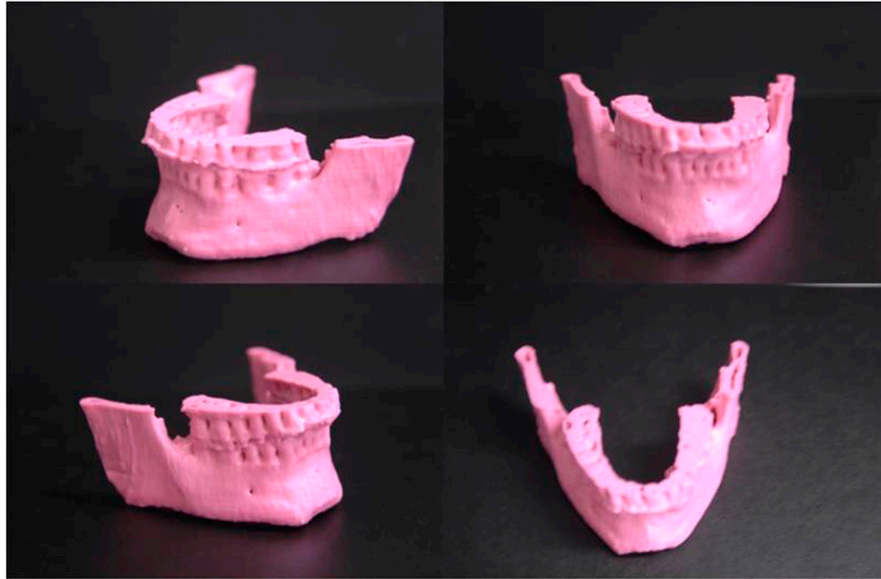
The first three-dimensional printed anatomical model ever produced from "Black Bone" MRI of the mandible of an adult volunteer.
